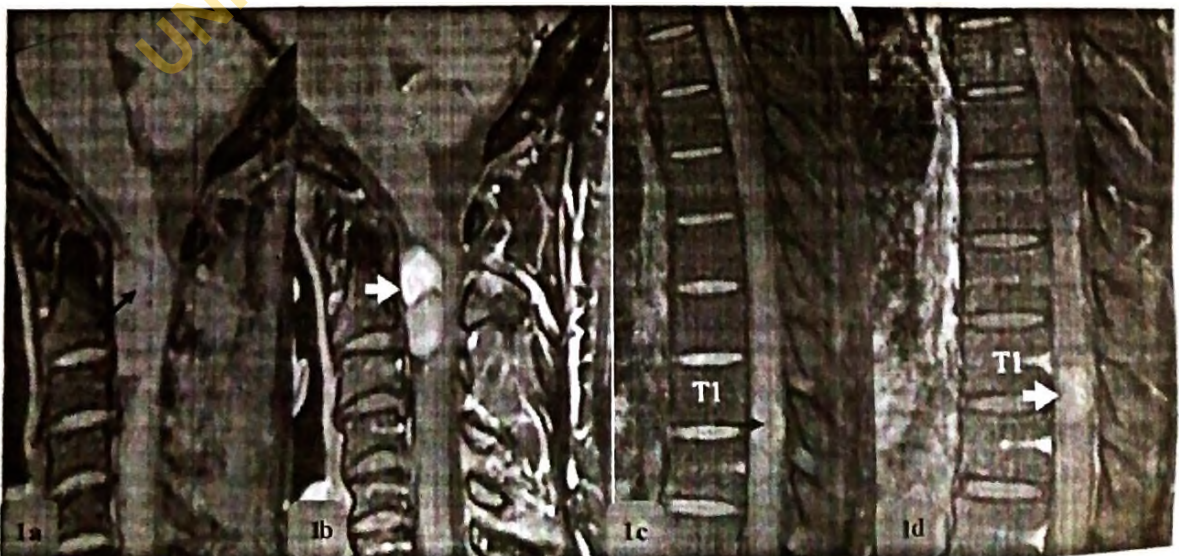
(a-d): Spinal magnetic resonance imaging
